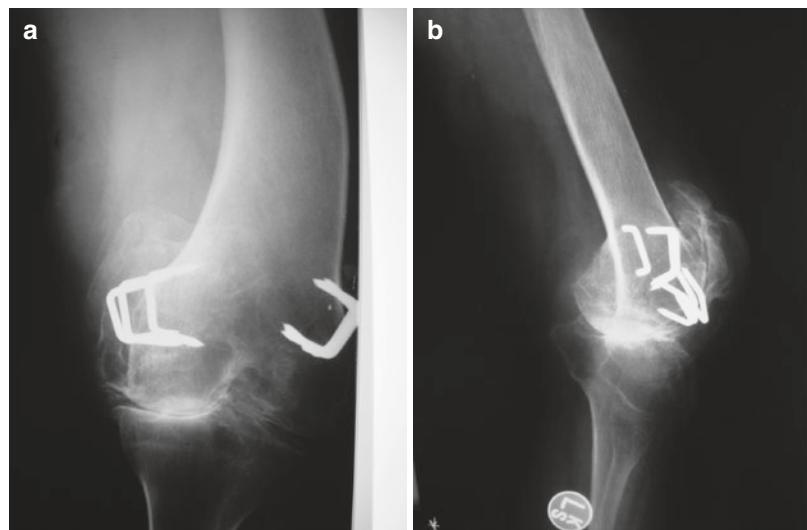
Anteroposterior X-ray of the knee (a, b) with the epiphysiodesis staples in place
